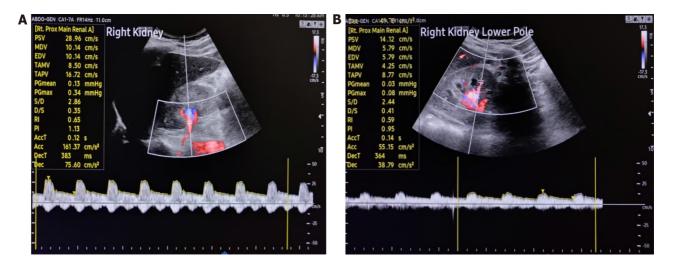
Measurements of the renal resistive index. A and B: Using a duplex Doppler ultrasound machine at right renal artery at hilum (A) and right lower interlobar artery (B).
